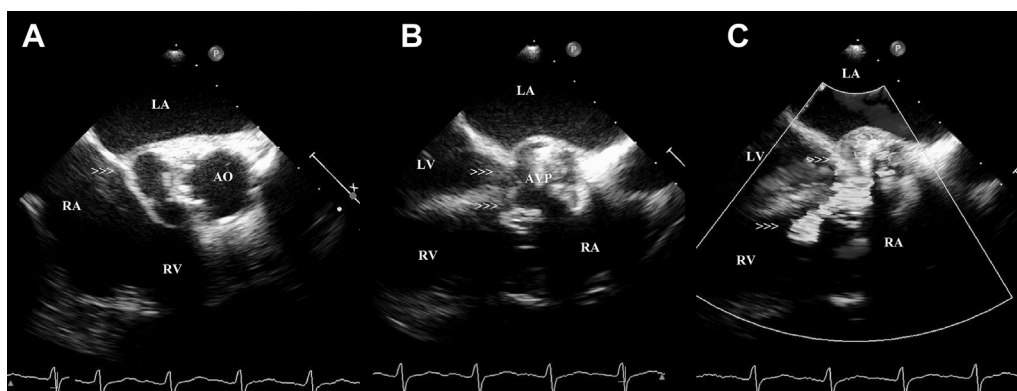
Transesophageal echocardiogram (TEE) showing a large aortic root pseudoaneurysm involving right coronary cusp extending from aortic valve prosthesis in a patient with aortic valve prosthetic endocarditis (A, arrowheads). Note pseudoaneurysm to biventricular fistulous connection (B, arrowheads) with color Doppler flow across these fistulous tracts (C, arrowheads). LA, Left atrium; RA, Right atrium; LV, Left ventricle; RV, Right ventricle; AO, Aorta; AVP, Aortic valve prosthesis.
